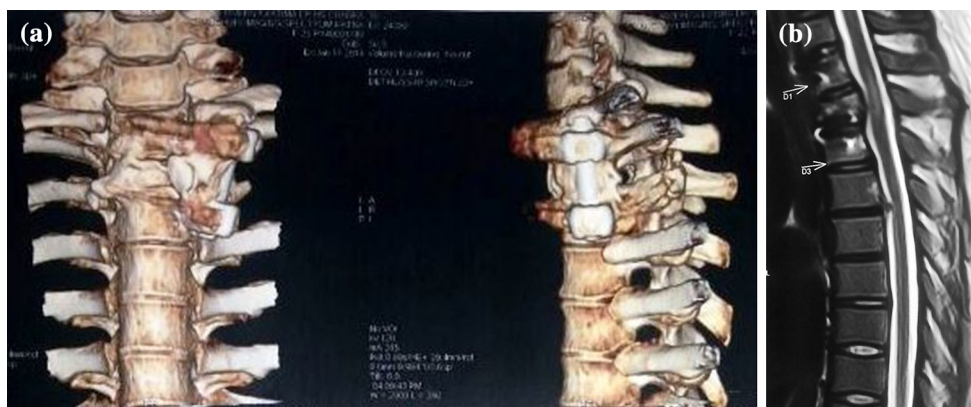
3-D reconstruction CT scan (a) and MRI Sagittal T2 weighted image (b) at 14 months follow up
